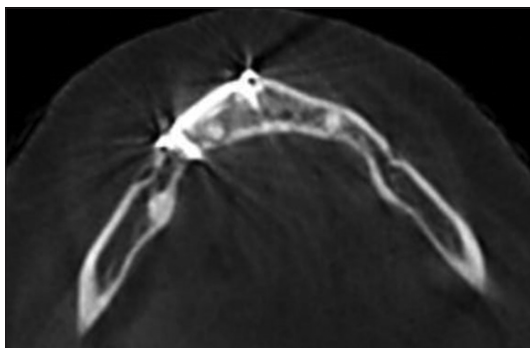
Third day cone-beam computed tomography scan was taken to assess the reduction in lingual splay is checked on the axial view, complete reduction in lingual splay can be seen
